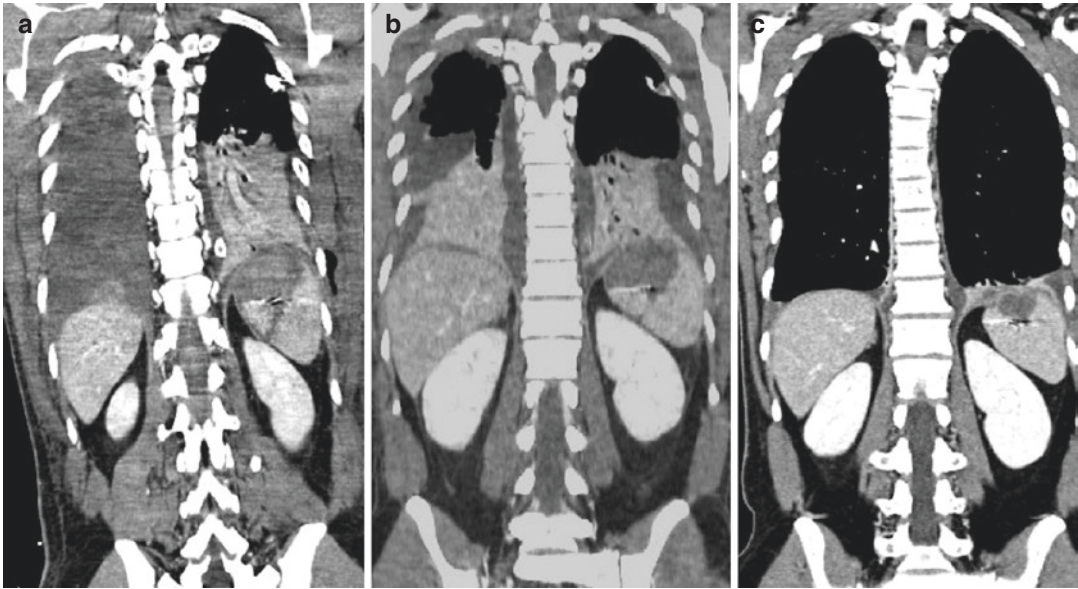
Same case of Fig. 16.17. CT follow-up after treatment with distal embolization of the previous case: the splenic infarct area is spontaneously reduced in size as
